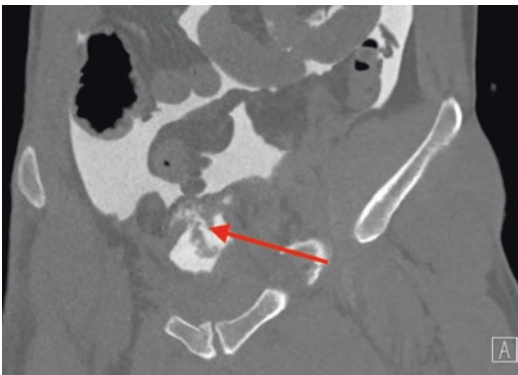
Coronal CT of the pelvis after injection of contrast agent into the urinary bladder via a urethral catheter. A large defect in the superior aspect of the bladder (red arrow) represents an intraperitoneal rupture of the bladder with contrast outlining the bowel and mesentery
